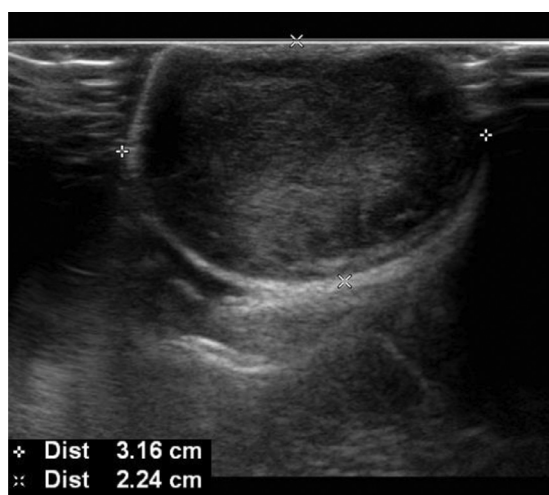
Ultrasound shows a solitary well-circumscribed heterogeneous hypoechoic mass with a maximal diameter of 3.2 cm behind the left areola.
